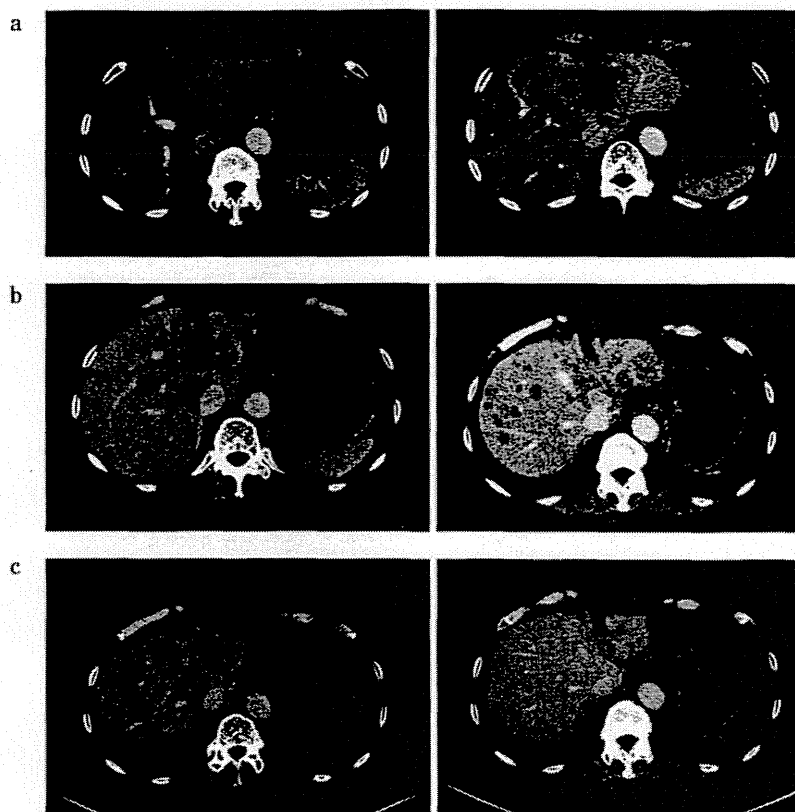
a: Abdominal CT when first finding multiple liver metastases and left portal vein tumor embolus of rectal cancer.
